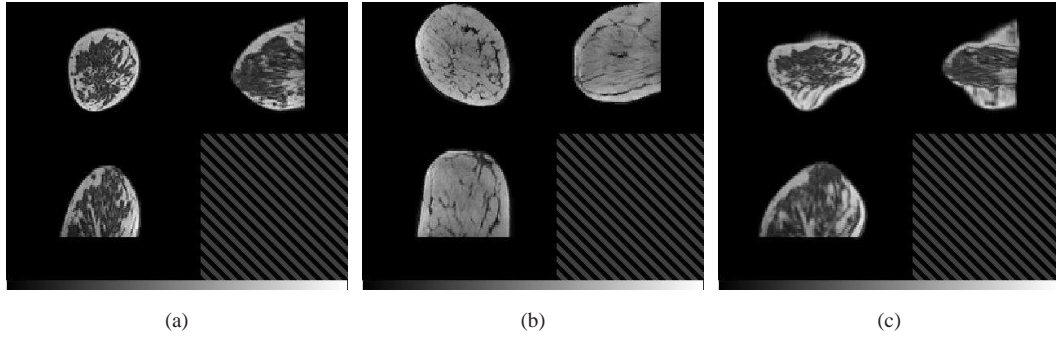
(a) MRI of patient p1; this is chosen as the space where all deformations are mapped for the SDM. (b) MRI of another patient p2 used for the construction of the SDM. Initially compressions are applied to all patients and then these are mapped to p1, where PCA will be used to extract the main modes of variation. (c) Deformed MRI of p1, after applying the displacement field of p2, mapped into the space of p1 using an affine registration. The anomalous shape of the breast in (c) is caused by the large difference in breast shape between p1 and p2 (particularly obvious in the coronal view) which is not compensated for by the affine registration.
